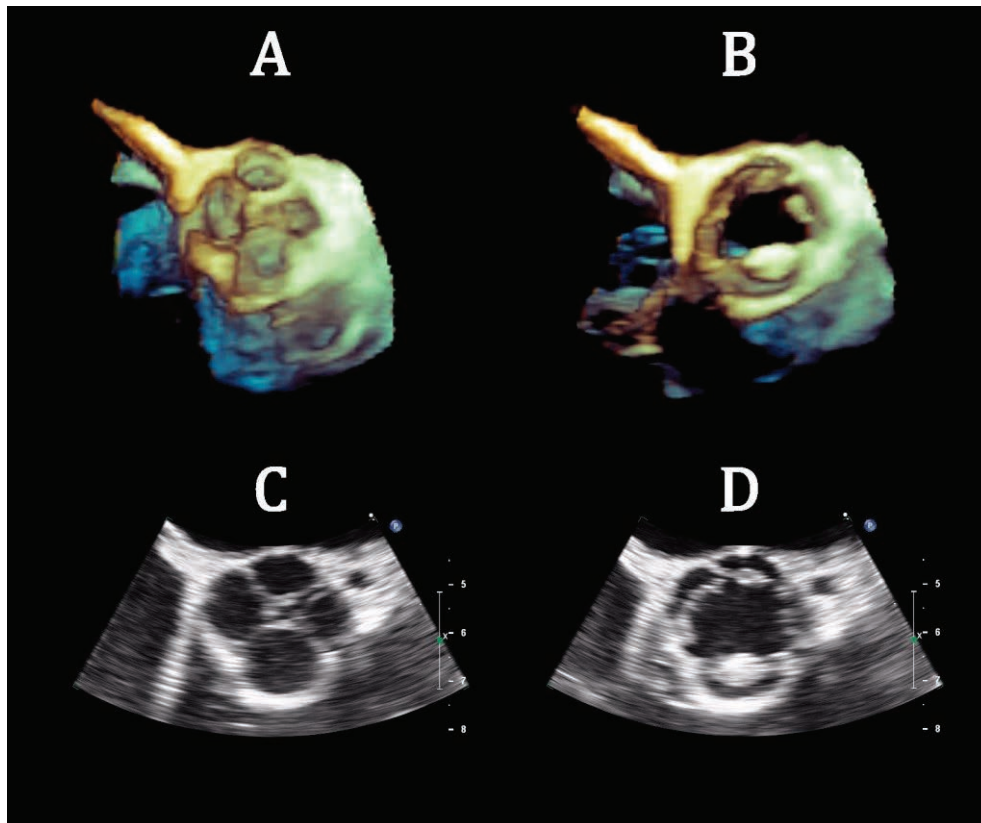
Transesophageal echocardiogram of a quadricuspid aortic valve during diastole (A and C) and systole (B and D).
